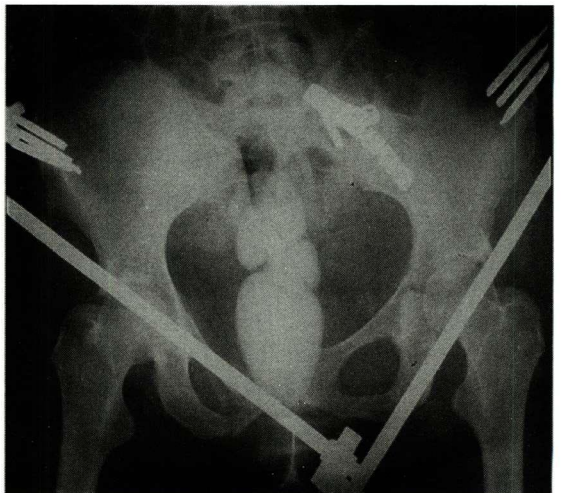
Radiograph with external fixator in situ
